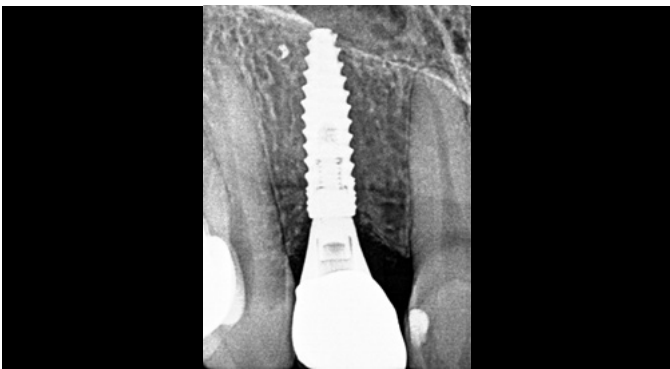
Final radiograph showing implant integration and bone preservation
